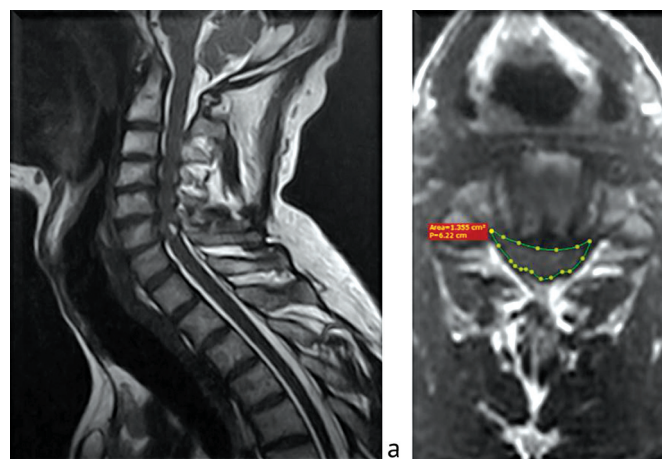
MRI of the patient's cervical spine before surgery: a sagittal view; b axial view
